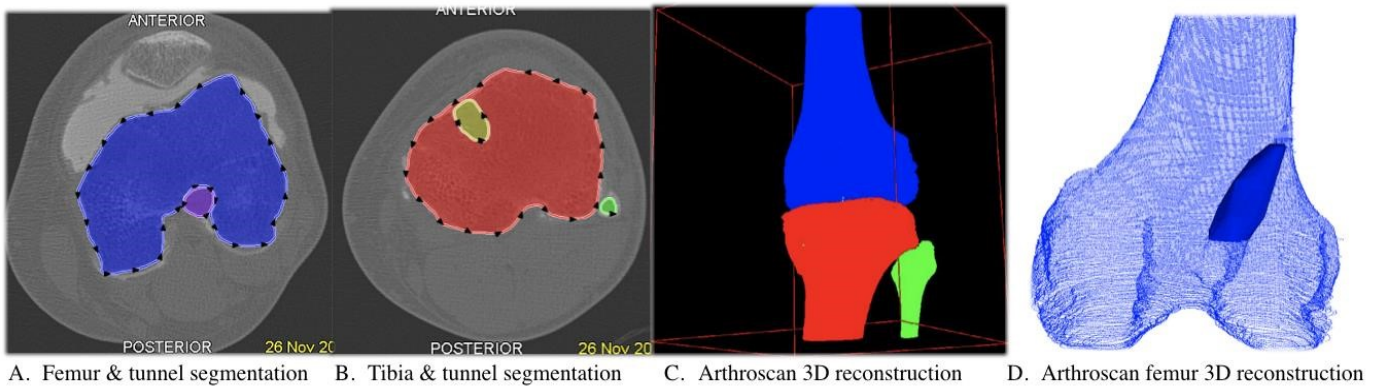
CT-Scan segmentation and reconstruction
